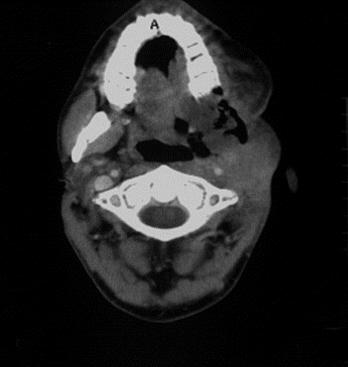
CT scan of a patient with recurrent SCC after surgery and radiotherapy, prior to Foscan®-mediated PDT (note: tumour mass marked).
